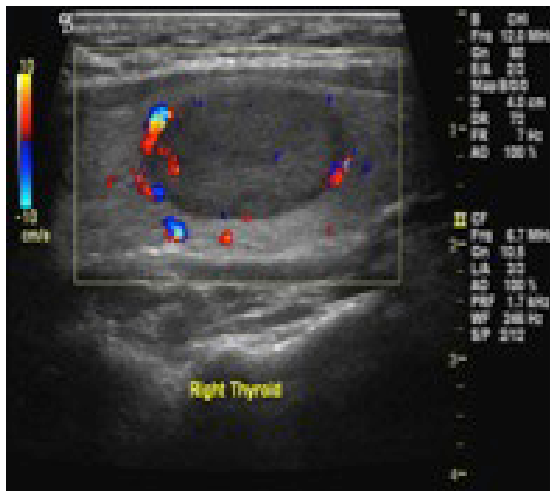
Ultrasound (Left) shows hypoechoic nodule; well-defined with clear margins, and peripheral vascular flow, measuring 2.7x1.4 cm, there are no calcifications. Corresponds to the cold nodule seen on the Technetium Perchnetate ($^{99m}\text{TcO}_4$) thyroid scintigraphy (Right).
